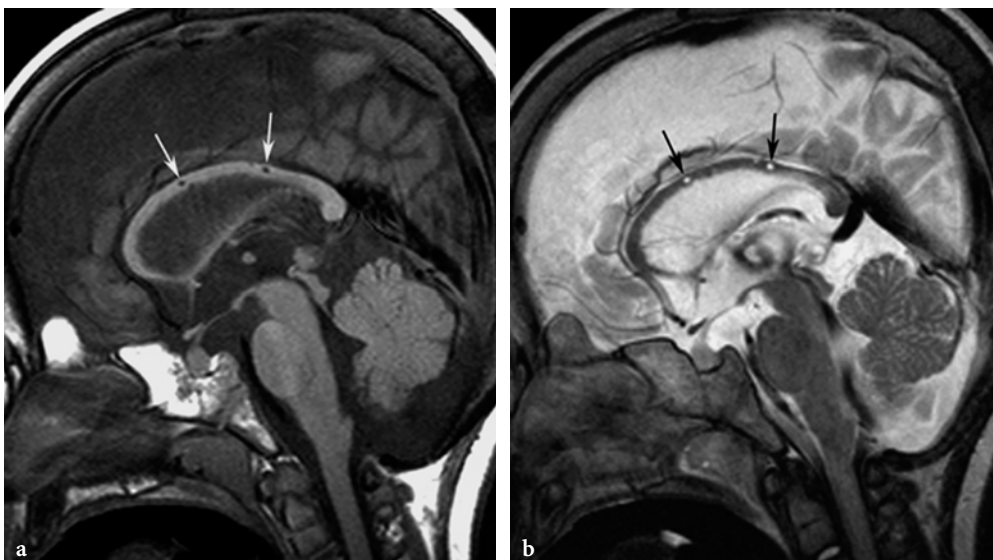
a, b. Enlarged perivascular spaces within corpus callosum in a 4-year-old female patient with mucopolysaccharidosis. a Sagittal T1-weighted spin-echo image. Enlarged callosal perivascular spaces (*arrows*). Note also the dysplastic odontoid process and the narrowing of the foramen magnum. b Sagittal T2-weighted fast spin-echo image. Similar findings
